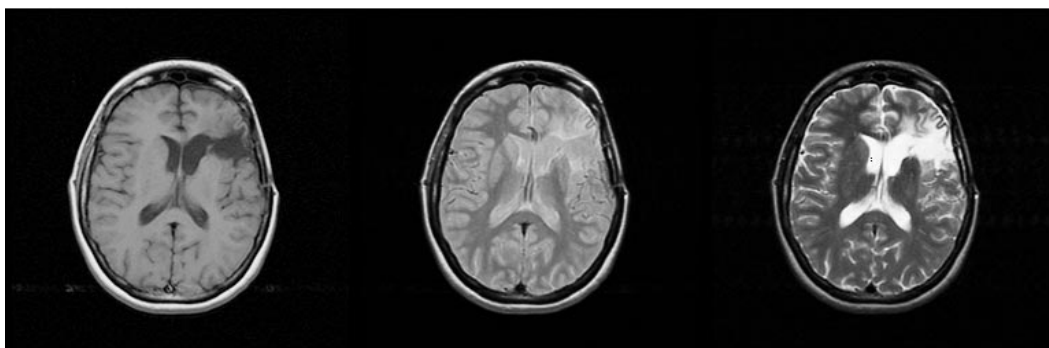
Sample raw data from a patient volume used for FCM clustering. Images shown are T1, PD and T2-weighted from left to right.
